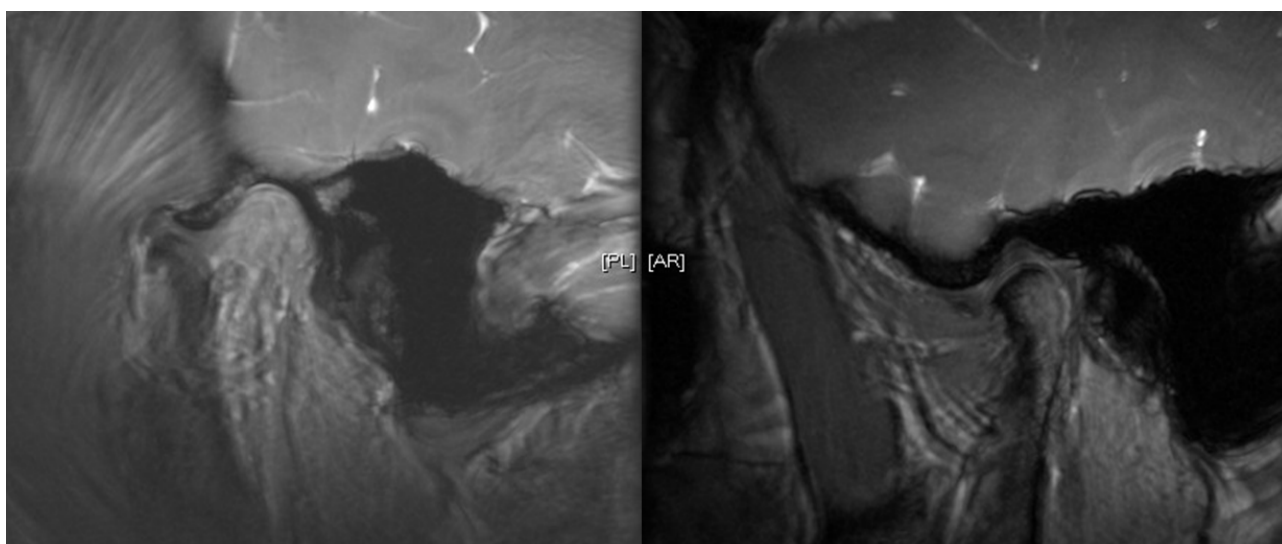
Mouth-opened and mouth-closed sagittal views of TMJ on T2-weighted MRI show the normal relation of articular disc and hard tissue components of TMJ.
